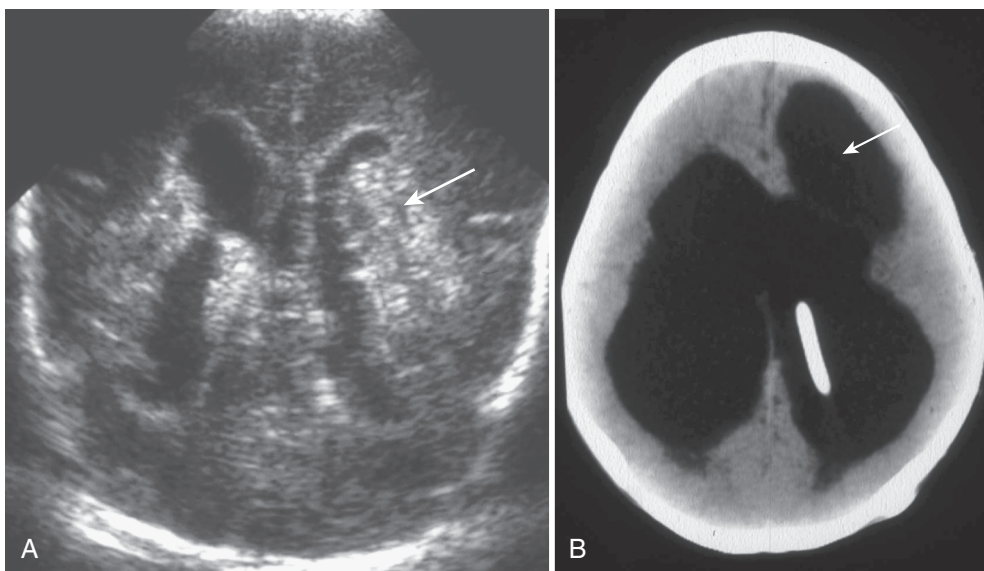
Periventricular leukomalacia. A, US scan of subacute phase with cysts (*arrows*). B, Axial FLAIR MR image of chronic phase with irregular ventriculomegaly and periventricular gliosis (*arrows*).
